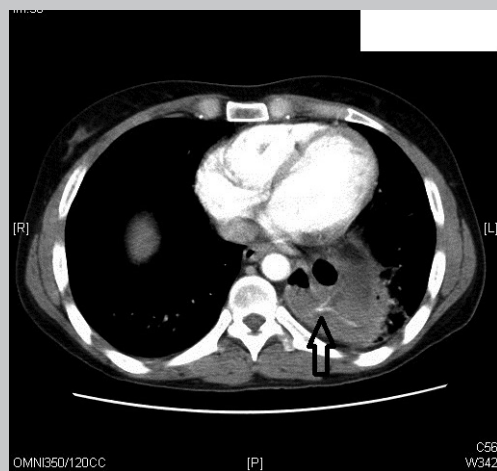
Computed tomography scan of chest and abdomen showing that the artery bifurcates within the bronchopulmonary sequestration.
